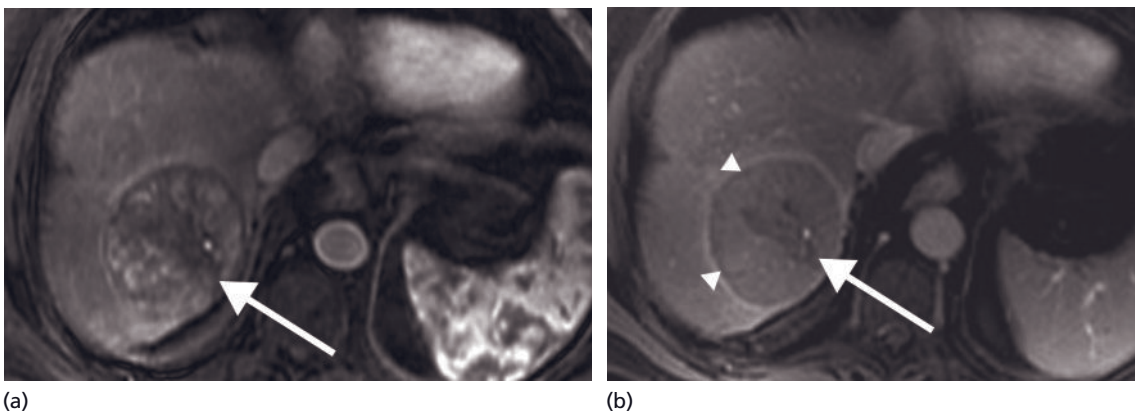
Hepatocellular carcinoma (HCC). (a) Axial, arterial phase contrast-enhanced MR image shows a heterogeneously, hypervascular mass (arrow) in this cirrhotic patient. (b) Portal-venous phase MR image demonstrates washout of this HCC (arrow), with a visible surrounding capsule (arrowheads).
